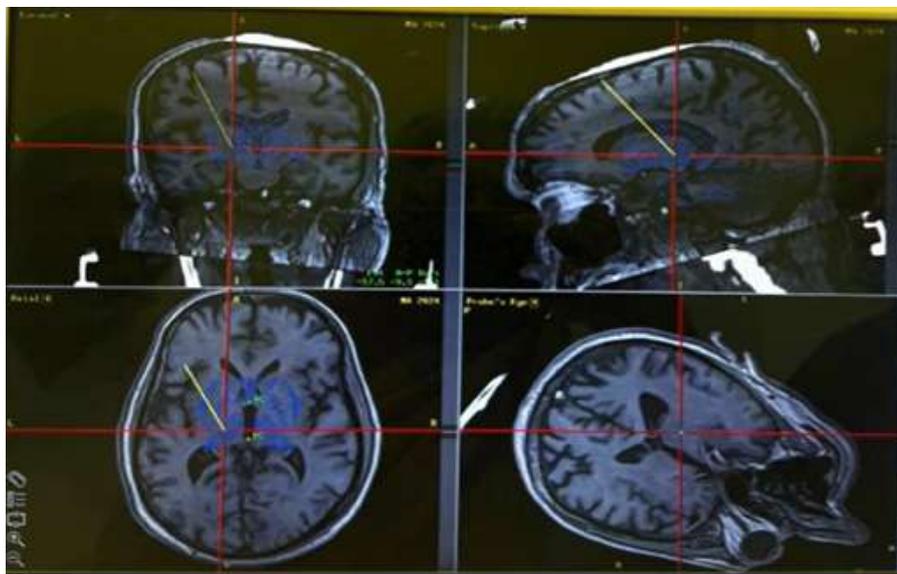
Preoperative stereotactic MRI-based target planning showing localization of the globus pallidus internus (GPi) and subthalamic nucleus (STN) for ablative surgery in Parkinson's disease. Red lines: marking target at point of intersection. Yellow line: marking trajectory from skull surface site to ablative target.
